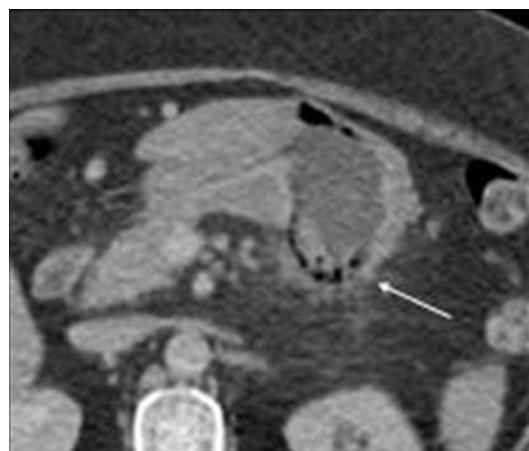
Gastric ulcer. Axial abdominal CT image of a 48-year-old man with NSAID use presenting with left upper quadrant pain shows a focal outpouching representing an ulcer along the lesser curvature of the stomach (arrow), with wall thickening and perigastric fat stranding representing associated gastritis
